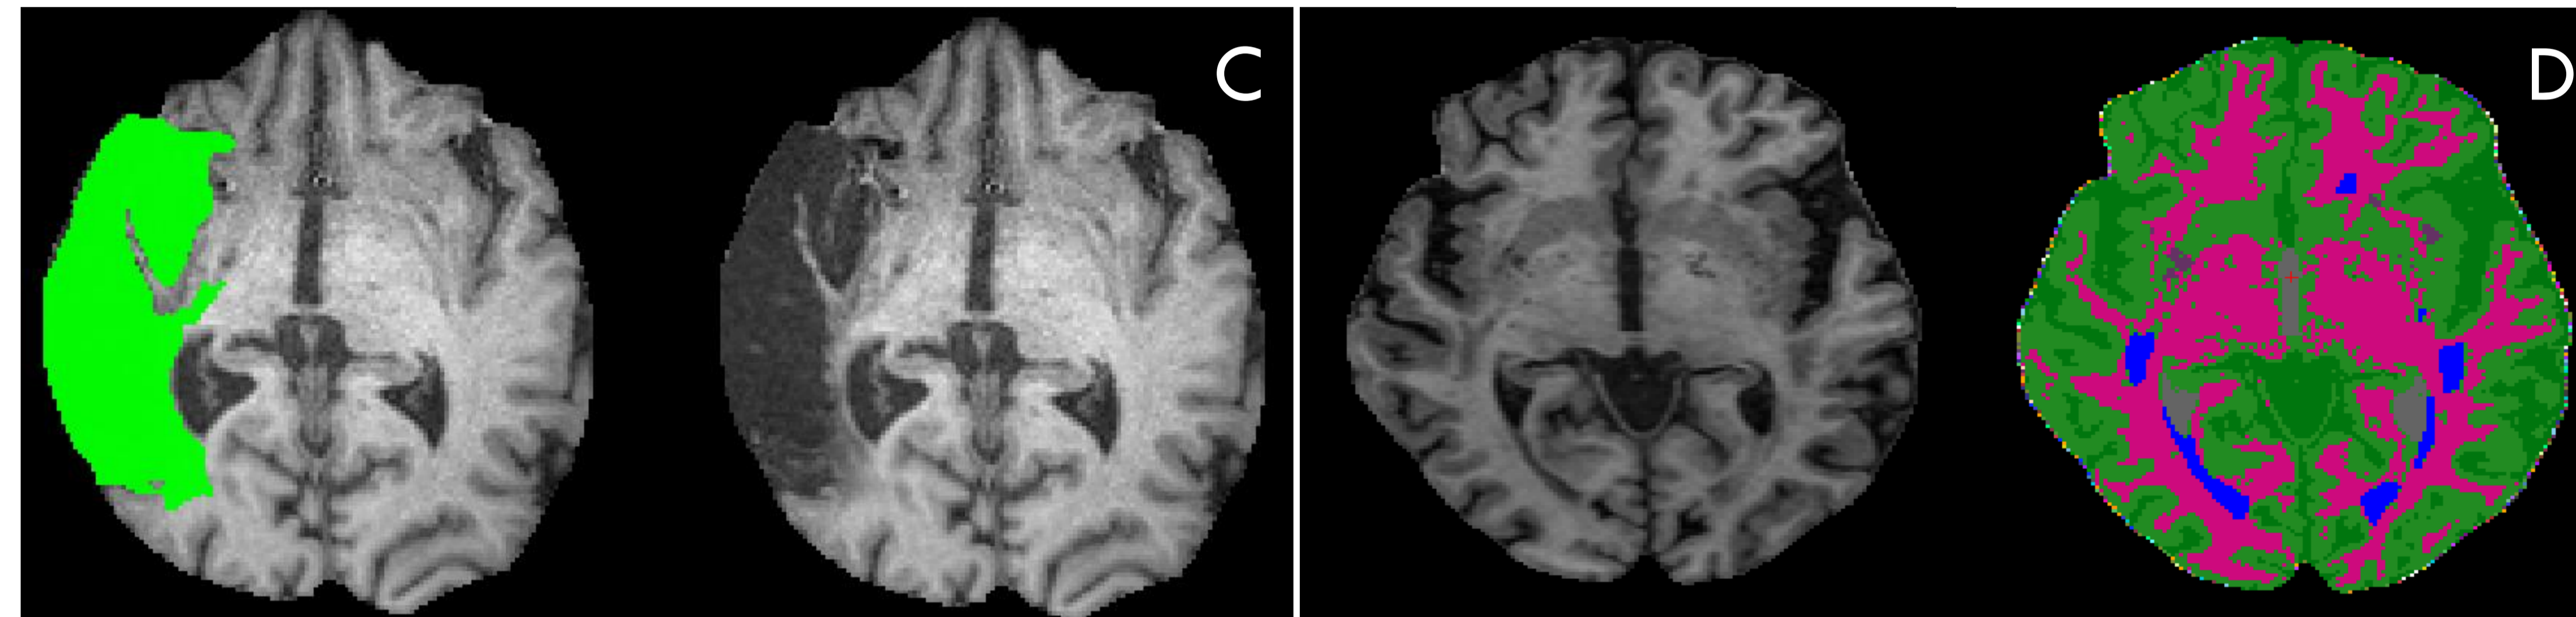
Manually traced cortical infarct mask overlaid on T1 slice (left). Stroke lesion was traced on T1 and co-registered Fluid attenuation inversion recovery (FLAIR) images. Figure D. Skull-Stripped T1 image (left) and segmentation (including white matter hyperintensities and stroke lesions (right)) from SABRE+LE were integrated into FS.
